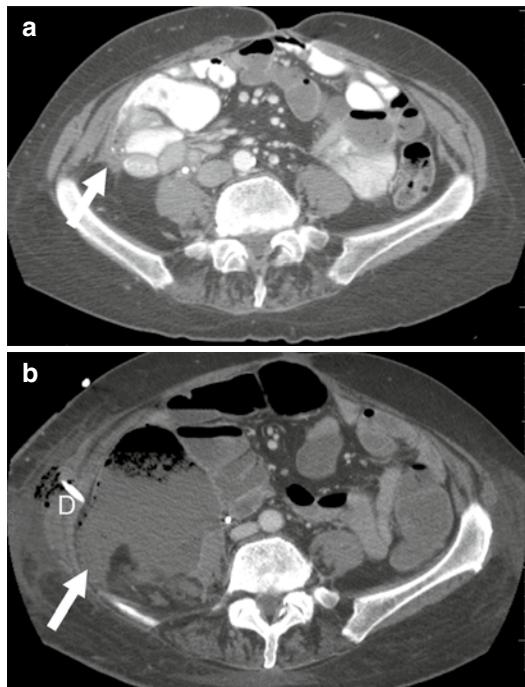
Perforation due to bevacizumab. A 60-year-old female with metastatic appendiceal carcinoma developed right lower quadrant abdominal pain, nausea, and vomiting 24 h after the administration of bevacizumab. (a) CT prior to therapy shows metastatic serosal implant (white arrow) adjacent to the small bowel in the right lower quadrant. (b) CT after the administration of bevacizumab shows interval development of perforation and abscess formation (white arrow) in the right lower quadrant. The patient underwent percutaneous drainage (*D*); there is air and stranding near the drain. The presence of serosal implants is a risk factor for perforation while on treatment with bevacizumab
